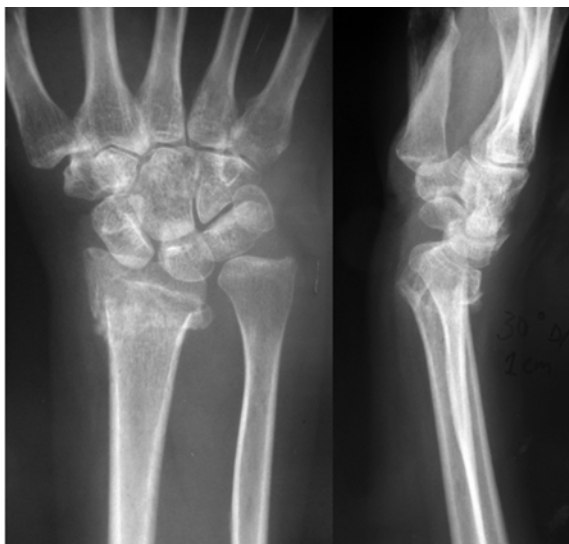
Posteroanterior (left) and lateral (right) radiograph of the right wrist reveal a dorsally displaced extra-articular distal radius fracture. The fracture is closed to the “watershed” area and surrounded by a callus formation
